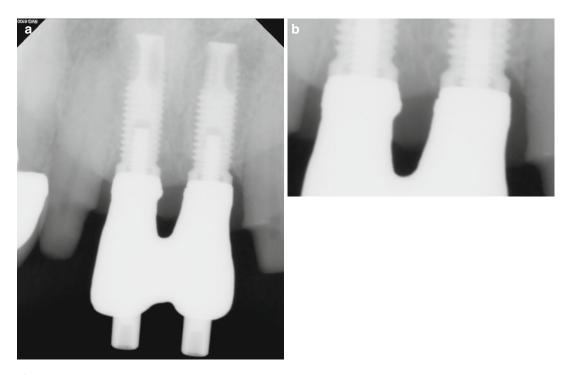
(a, b) Radiograph at metal try-in appointment. Enlarged image shows intimate contact of both abutments with the implants
